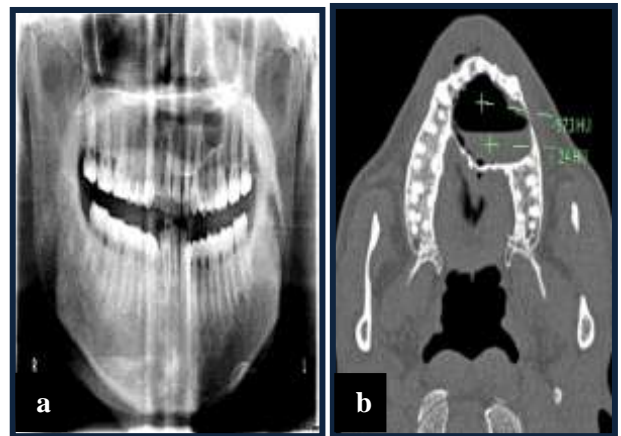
Infected radicular cyst: Well-defined, homogeneous radiolucency extending from 12 to 26 in a panoramic radiograph.
